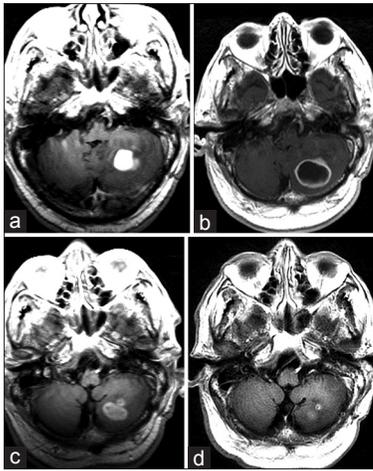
Evolution of TB Cerebellar Abscess. (a) Contrast enhanced axial T1 at 4-month follow up shows enhanced thickened and nodular cavity wall, which was unchanged in size or appearance from the postoperative 1 month follow up MR (not shown). (b) Axial T2 FLAIR at 9-month follow up showed increased cavitation size, but with decreased capsule thickness and nodularity. (c) Contrast enhanced axial T1 at 11-month follow up showed decreased size of the lesion, without change in treatment. (d) Contrast enhanced axial T1 at 14-month follow up shows significant reduction in size of previously noted cavitory lesion
